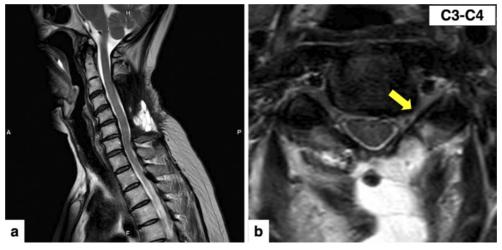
Postoperative T2-weighted MRI images showed the posterior shift of the cord (a) and the slight left C3–C4 foraminal stenosis at the yellow arrow (b).
